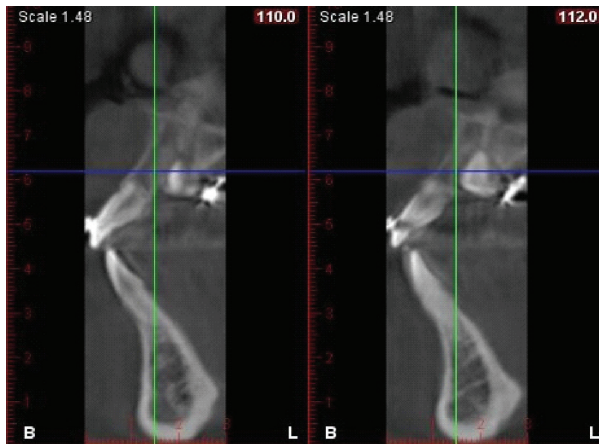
A cross-section of the same patient showing the damage to the root of the central incisor using CBCT.
